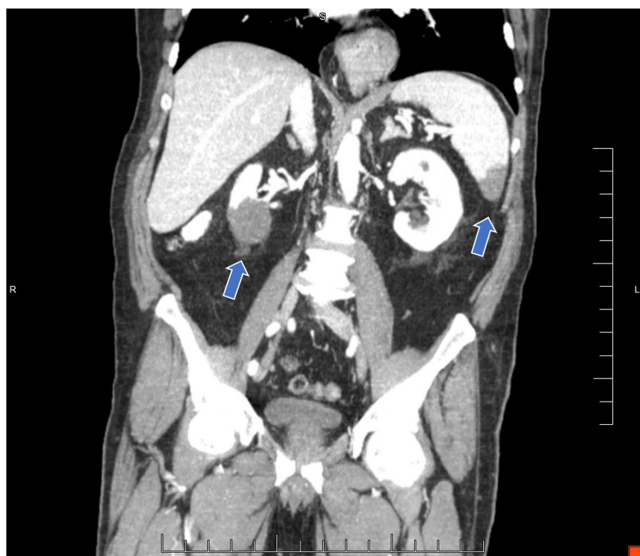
CTA of the abdomen and pelvis demonstrating splenic and renal infarcts (arrows).
